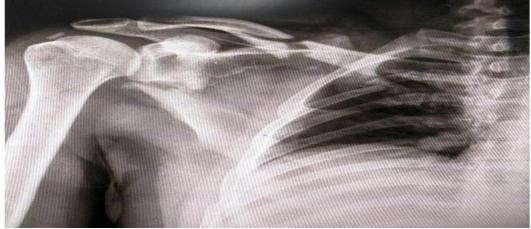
Case 1: Pre-op X-ray (Clavicle Type I, Scapula Goss Type II GPA <30°)
